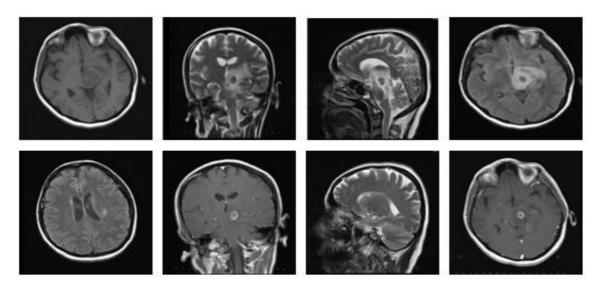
T1A iso-hypointense, central hypointense and peripherally hyperintense in T2A and FLAIR sequences, peripheral enhancing abscess lesion at left thalamus, capsule interna and mesencephalon causing mass effect with intense edema and a second abscess lesion at adjacent to the anterior horn of the lateral ventricle on the right.
